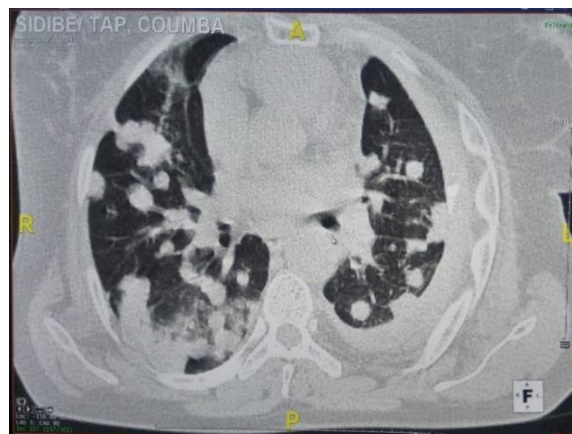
Thoracic CT scan in axial section and parenchymal window (a): after injection of contrast product, highlights bilateral parenchymal and subpleural nodules with balloon release and pleurisy
